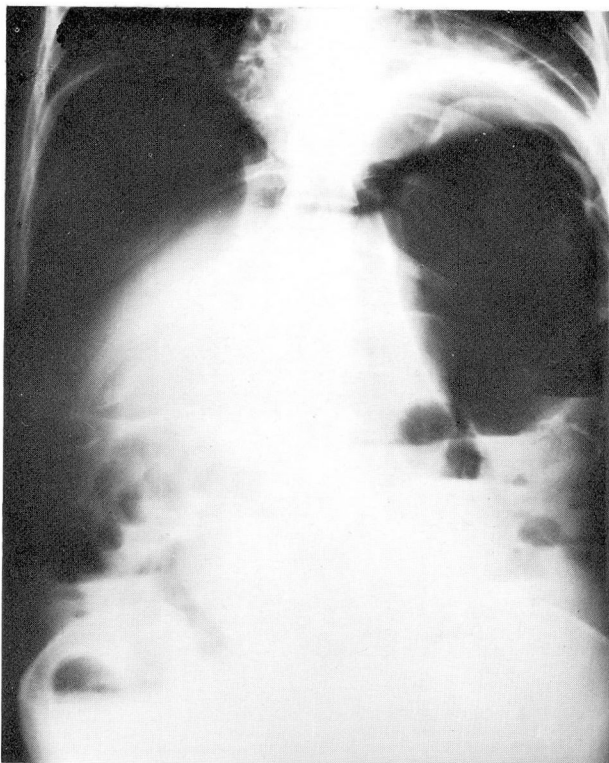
Roentgenogram of the abdomen on December 13, 1964, with the patient standing. A large amount of free air in the peritoneal cavity is evident, associated with elevation of the diaphragm. Air-fluid levels are present in minimally distended large and small intestines. (Courtesy of Charles E. Staats, M.D., Charleston, West Virginia.)
